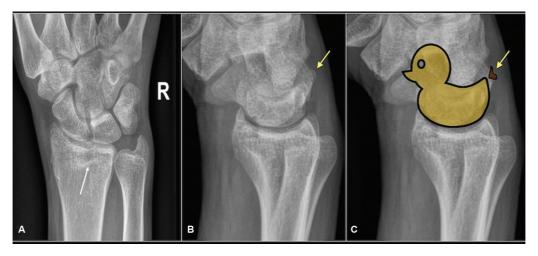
Anteroposterior (A) and lateral (B, C) radiographs of the right wrist. Fractures of the distal radius and triquetrum seen (arrow). The arrow points to an avulsed fragment from the dorsal cortex of the triquetrum. "Poop" in the pooping duck sign refers to the avulsed fragment (C).
